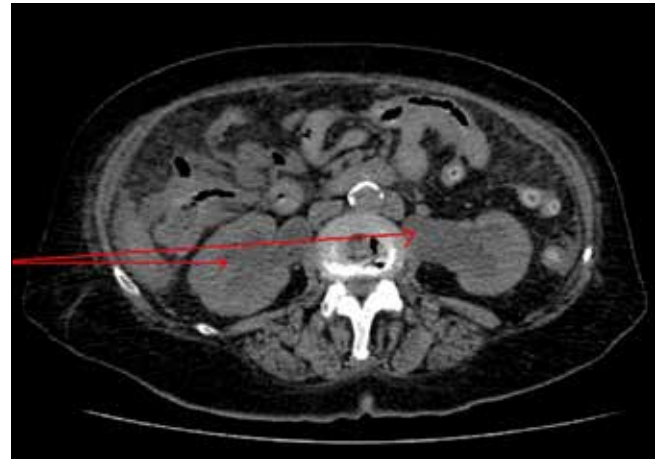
Image of CT AP showing bilateral hydronephrosis
